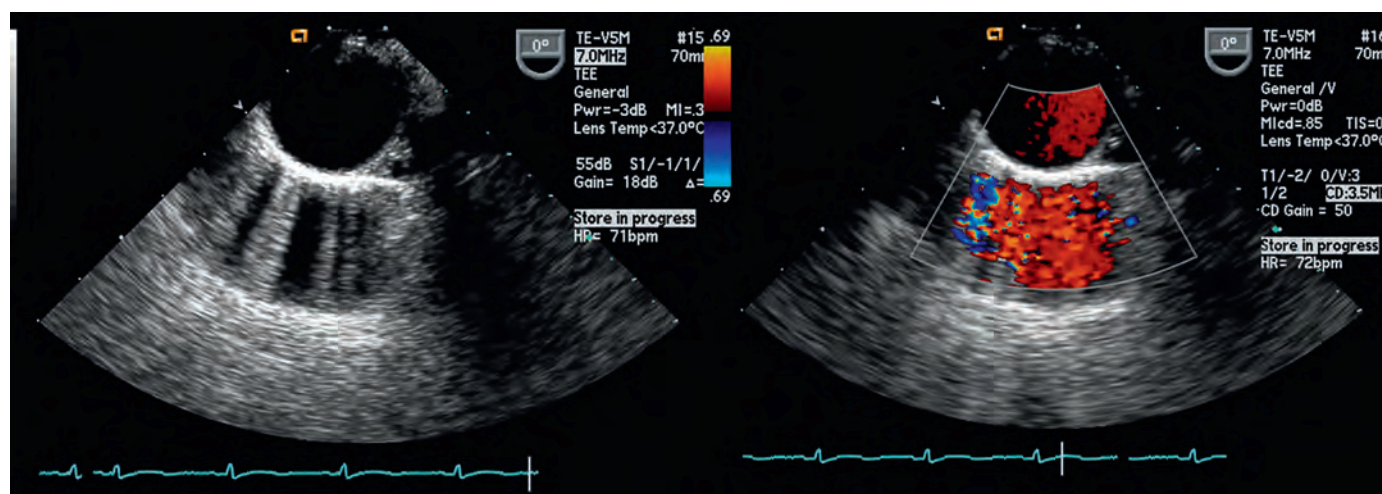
Mirroring artifact; descending aortic short-axis view. The descending aorta is best imaged at the top of the figure. Because ultrasound waves are trapped within the aortic wall, a secondary image appears deeper to the original image. When color-flow Doppler is added to the image on the right, flow appears in both the top original image and in the mirror image.
